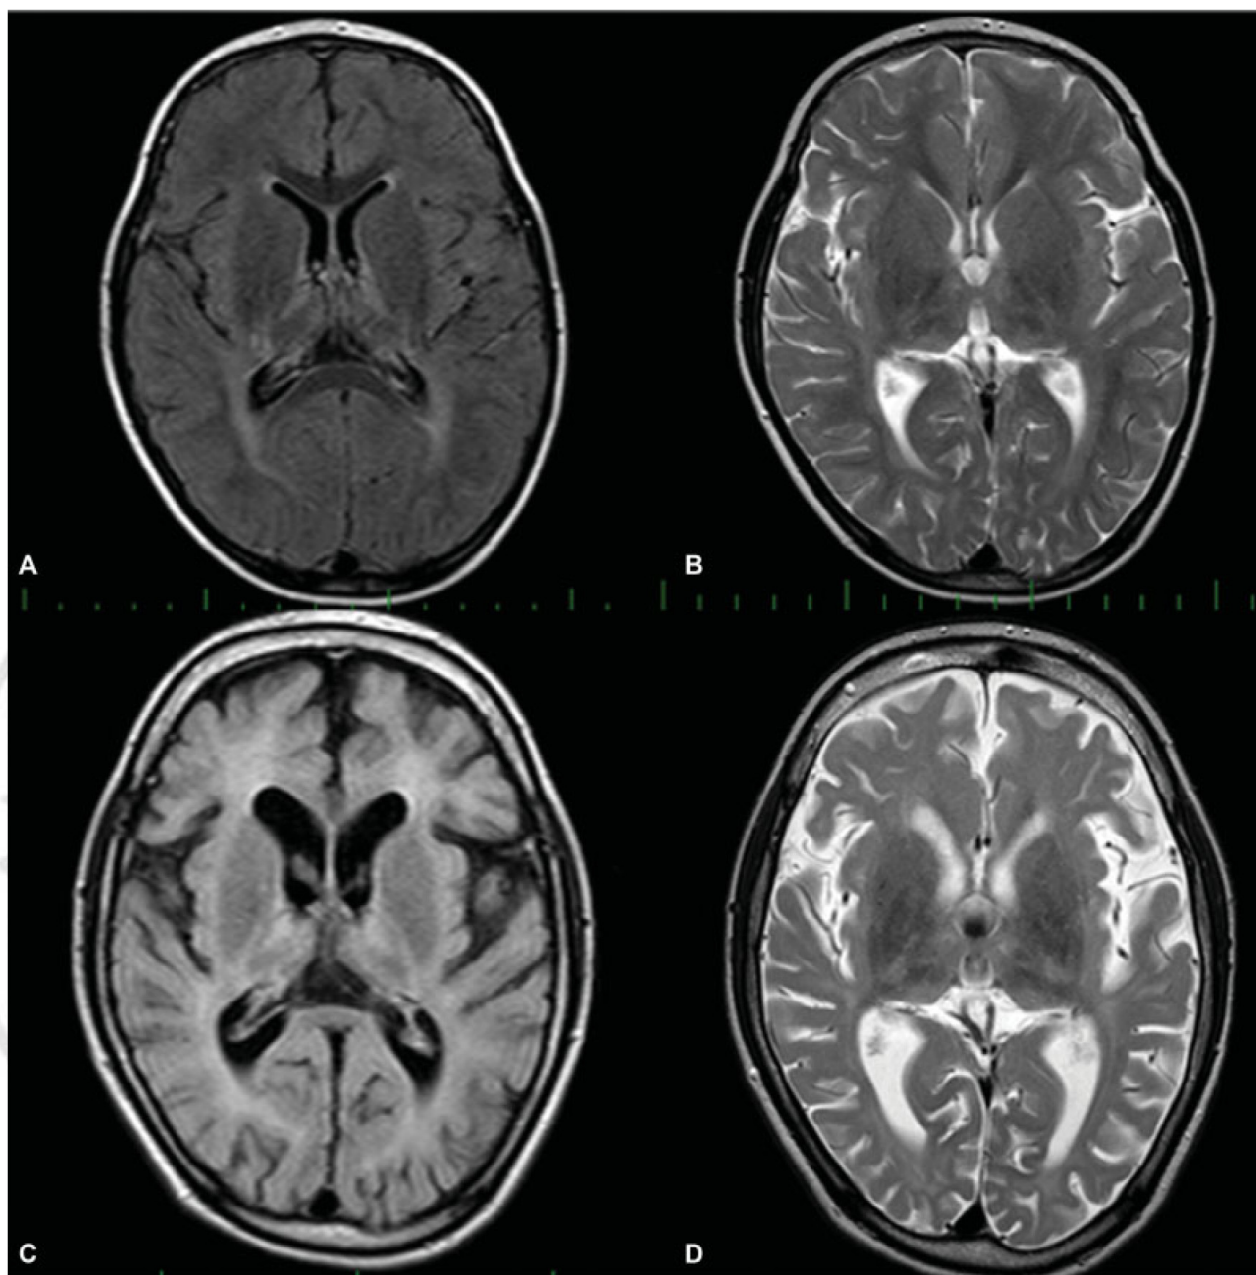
Representative MRI slices from the patient. FLAIR (A) and axial T2-weighted (B) image at the age of 3 years—bilateral signal hyperintensity in the parieto-occipital white matter in FLAIR image. FLAIR (C) and axial T2-weighted (D) image at the age of 7 years—severe diffuse brain atrophy. T2 and FLAIR MRI images at both ages show bilateral symmetric hyperintense areas in ventromedial and dorsal thalamus. MRI, magnetic resonance imaging. FLAIR, fluid-attenuated inversion recovery.
